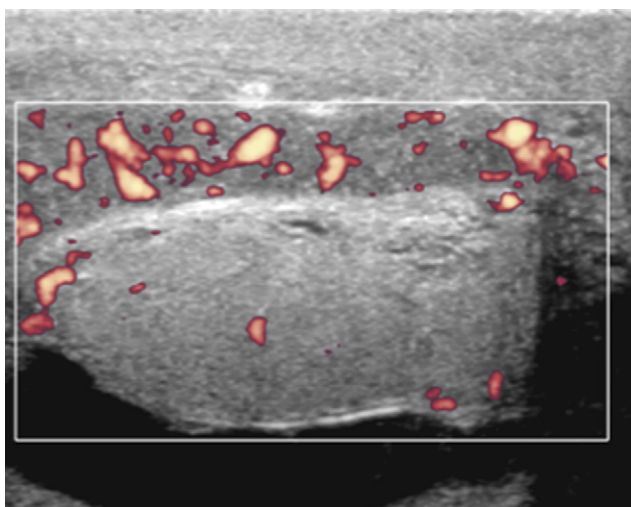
Epididymitis. Power Doppler sonography: isolated hyperaemia in the epididymis and the testicular parenchyma presents normal vascularisation.
